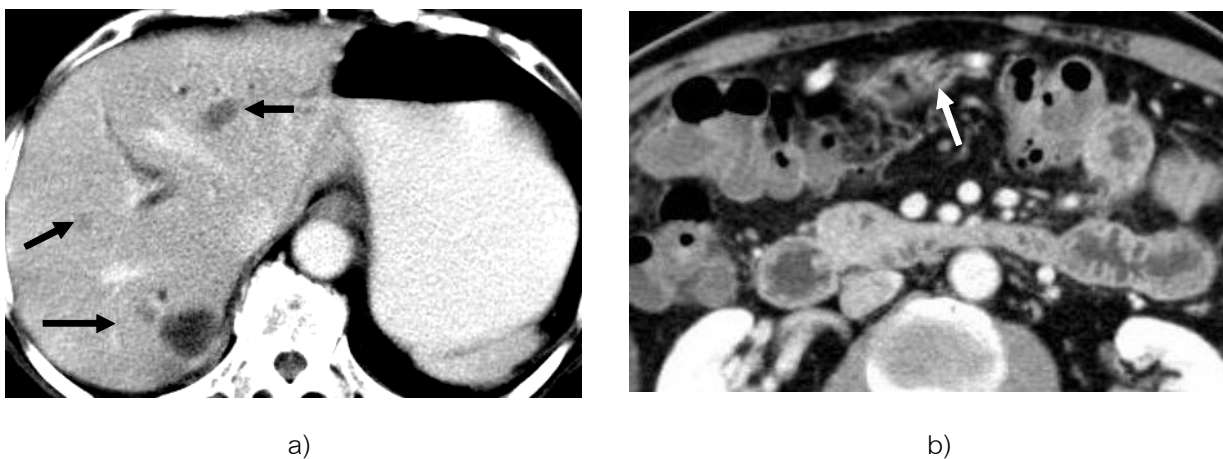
Metastasis. a). CT scan of a 67-year-old with diagnosis of moderately-differentiated pancreatic adenocarcinoma reveals multiple hepatic metastases (arrowed). b) CT scan of a 50-year-old shows enhancing soft tissue mass anterior to the transverse colon representing omental cake (arrowed).
